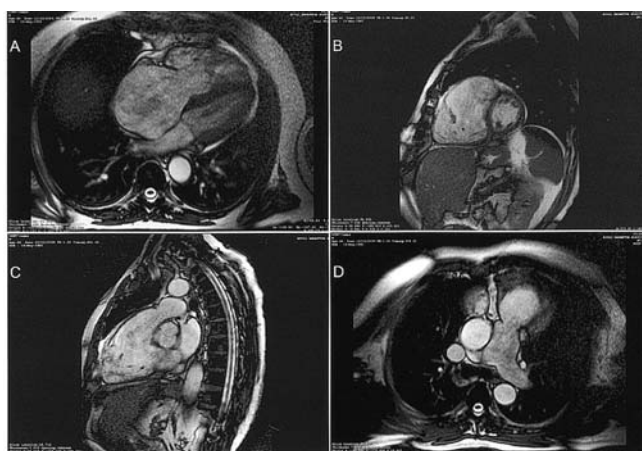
Magnetic resonance images. A) Four-chamber view showing a markedly dilated right heart and shrunken and immobile tricuspid valve leaflets, allowing free regurgitation. B) Short-axis view showing a dilated right ventricle and compression of the left ventricle. C) Right ventricular outflow tract. D) Fibrotic and shrunken pulmonary valve leaflets, allowing free regurgitation.
